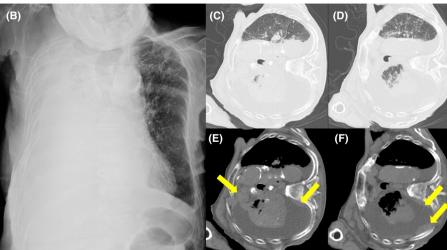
(A) Chest radiograph obtained 5 years before presentation shows a large fibrotic mass in the right upper zone (red arrowhead) and bilateral small nodules with upper-zone predominance. Pleural effusion is not seen. (B) Chest radiograph at presentation reveals right massive pleural effusions. (C–F) Chest computed tomography reveals multiple pleural tumors (yellow arrowheads) and bilateral pleural effusions with right predominance, in addition to small nodules in the left upper pulmonary lobe and enlarged hilar and mediastinal lymph nodes with calcification—typical findings in silicosis. Images (C) and (D) show the lung window, and images (E) and (F) show the plain mediastinal window.
